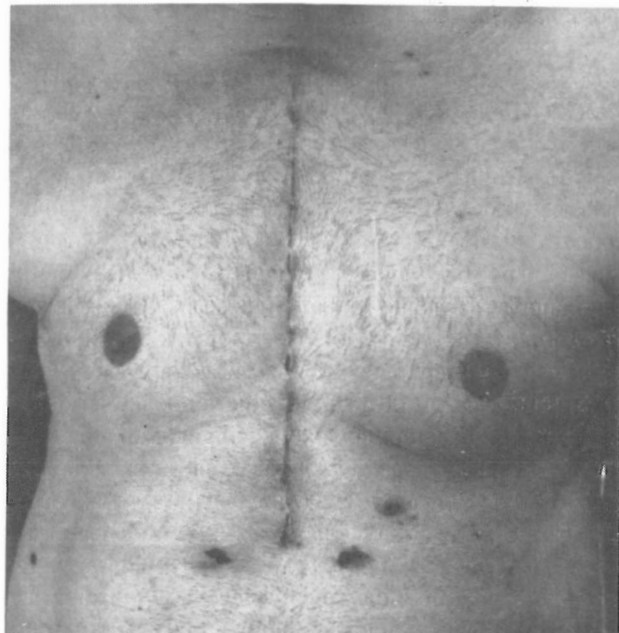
Postoperative photograph of the patient. Note old left parasternal scar.
